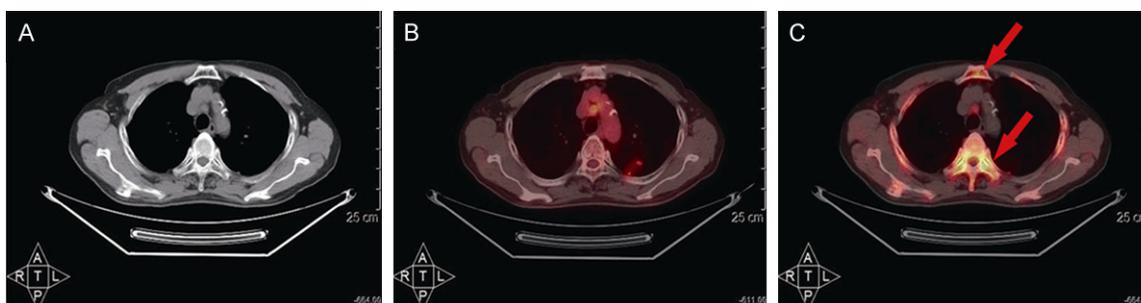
¹⁸F-FDG PET/CT showed no uptake in the bone. However, ¹⁸F-FLT PET/CT showed uptake in the sternum and vertebra. Pathologic examination revealed cellular reactivity in sternum and vertebra. A-C showed CT, ¹⁸F-FDG and ¹⁸F-FLT PET/CT imaging of patient 6, respectively.
